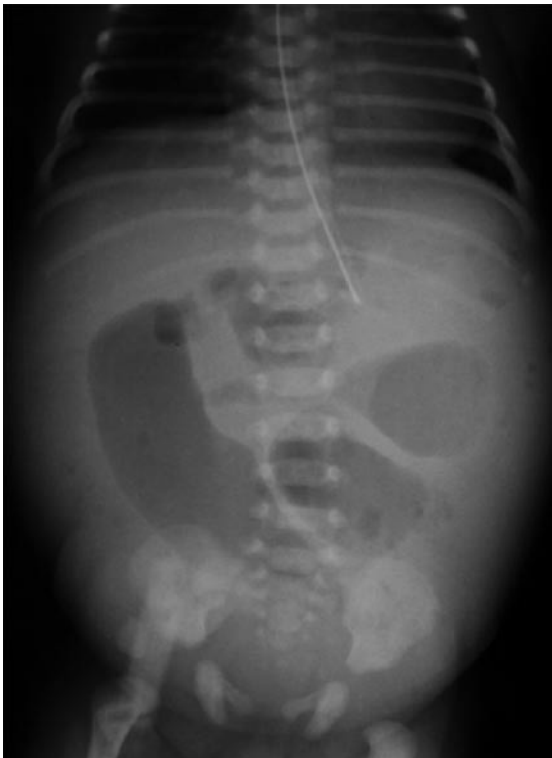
Abdominal radiograph shows dilated small bowel loops in the neonate.
